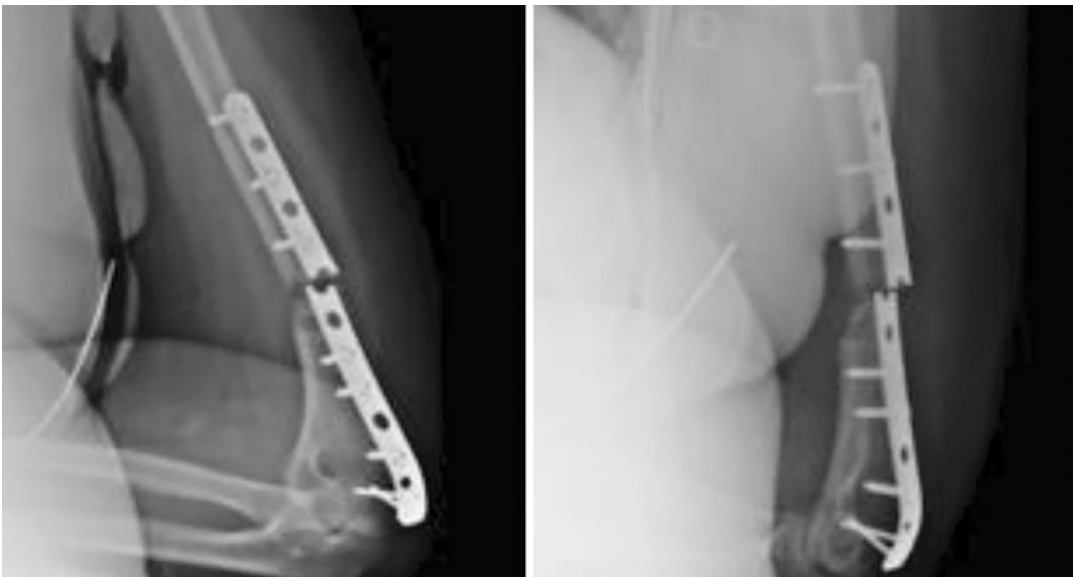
AP and lateral radiographs of left humeral atrophic nonunion
